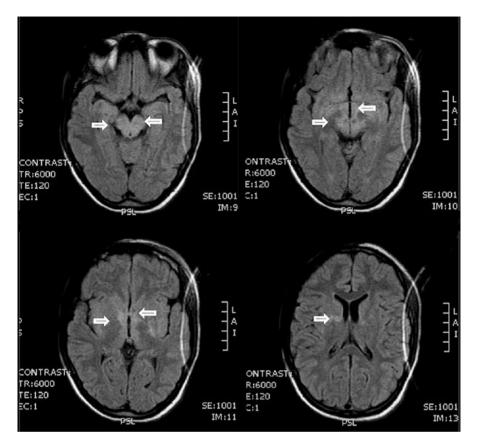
Axial T2 FLAIR-weighted images 2 years after initial MRI showing persistent hyperintense lesions in the mesencephalic region, surrounding the third ventricle and the aqueduct of Sylvius as well as in the basal ganglia. No gadolinium enhancement was found
